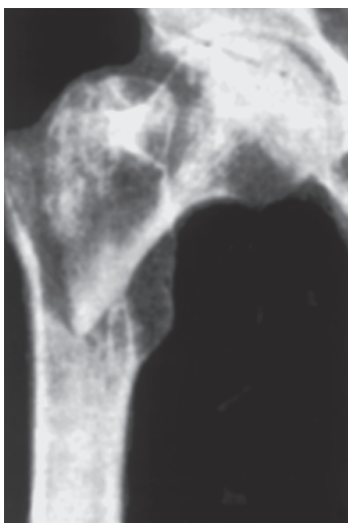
Radiograph showing comminuted trochanteric fracture femur
